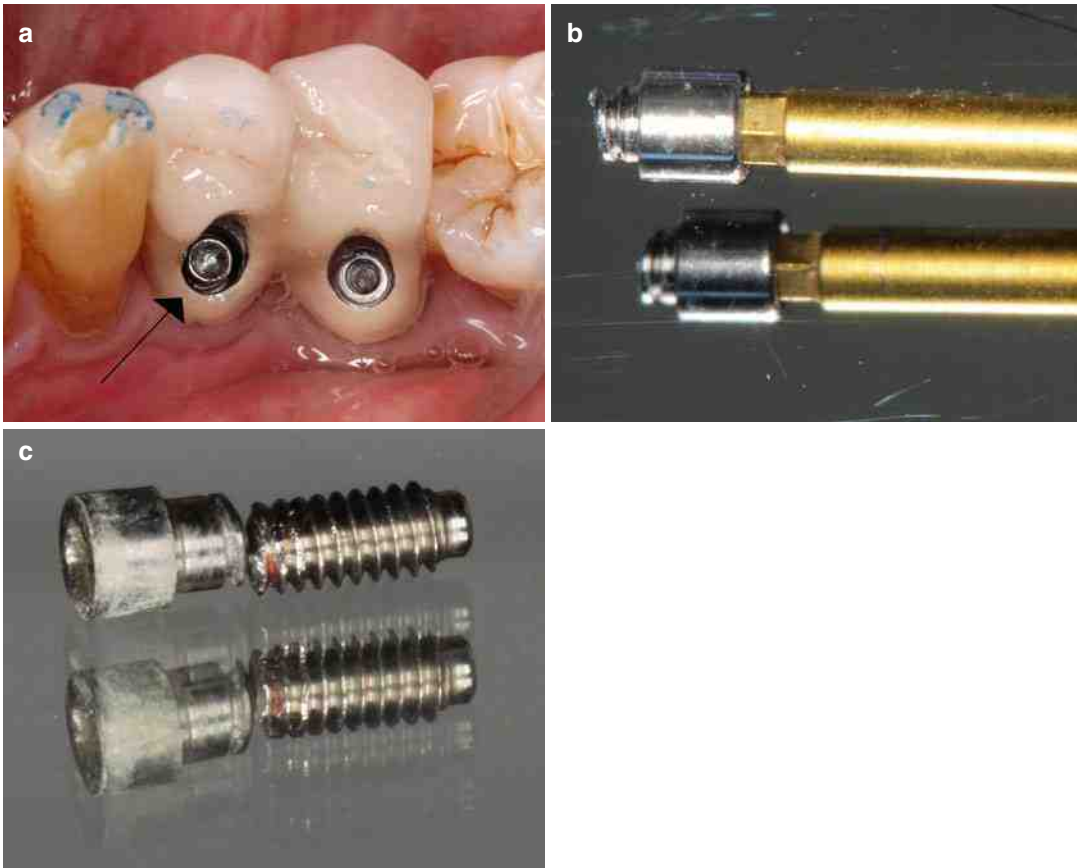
(a–c) The *arrow* indicates a fractured screw (a); coronal fractured portion of the screw removed with a driver (b); it was possible to retrieve the apical portion with the use of an ultrasonic tip (c)
